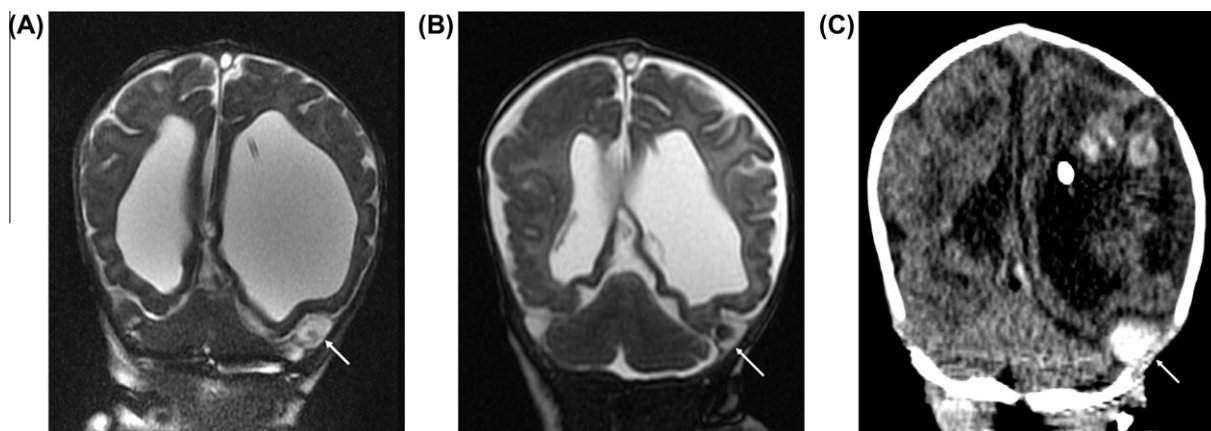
Images of a 2-month-old male, premature, 36 weeks gestation, with aqueductal stenosis and multiple sites of bleed post shunt (Patient 1). (A) Coronal Fast Imaging Employing Steady sTate Acquisition (FIESTA) brain MRI 3 days post ventriculoperitoneal (VP) shunt insertion; retrospectively, there was suspicion of thrombosis in the left transverse sinus (arrow). (B) Coronal FIESTA brain MRI 7 days post VP shunt insertion; retrospectively, there was suspicion of left transverse sinus thrombosis (arrow). (C) Axial non-contrast CT scan 7 days post VP shunt insertion showing thrombosis of the left transverse sinus (arrow) and parenchymal bleeding.
